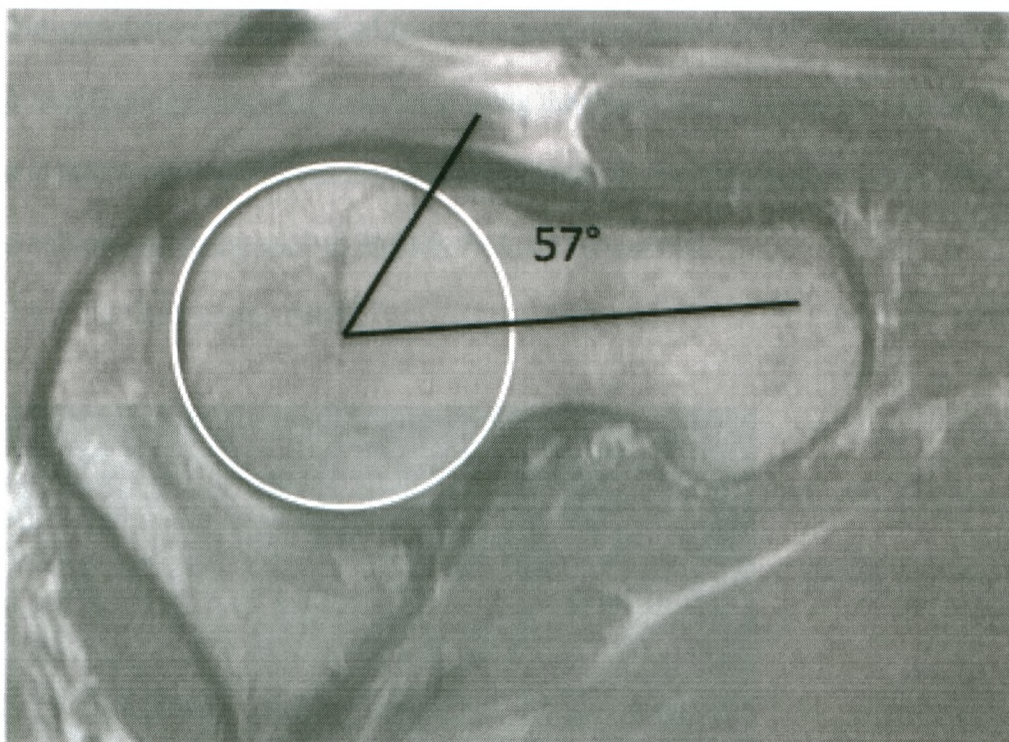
MRI of a 24-year-old male displaying an abnormal alpha angle of 57°.
